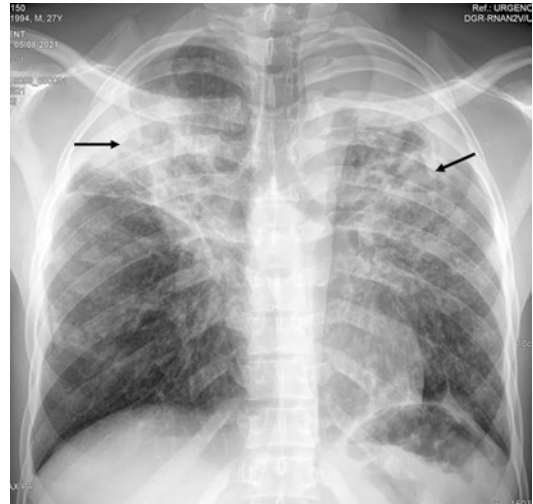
Tuberculosis reactivation in a 27-year-old man. AP chest radiograph shows retractile and cavitating opacities in both upper lung lobes (arrows) as well as multiple bilateral ill-defined nodules
